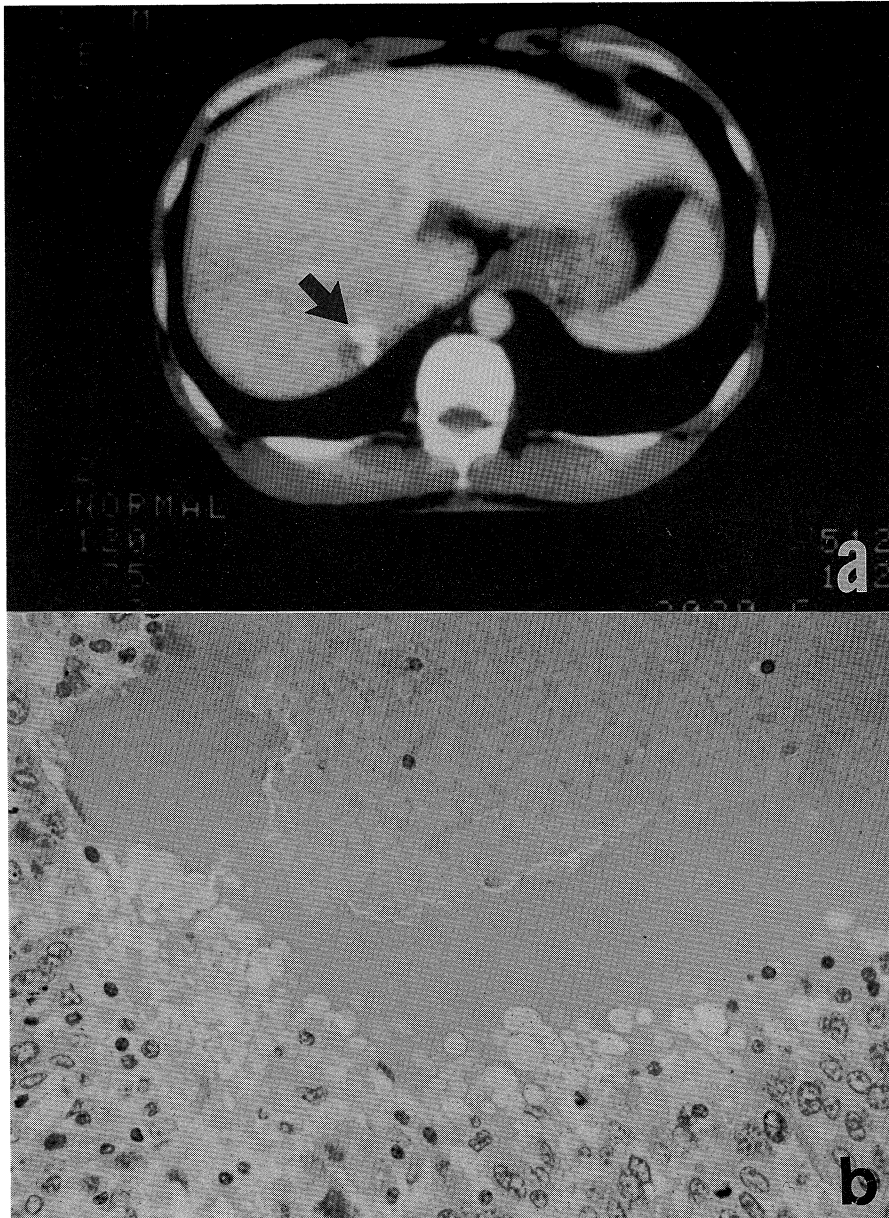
a. A CT scan one year after embolization shows the remnant of Lipiodol (arrow) within the tumor (case 2).
